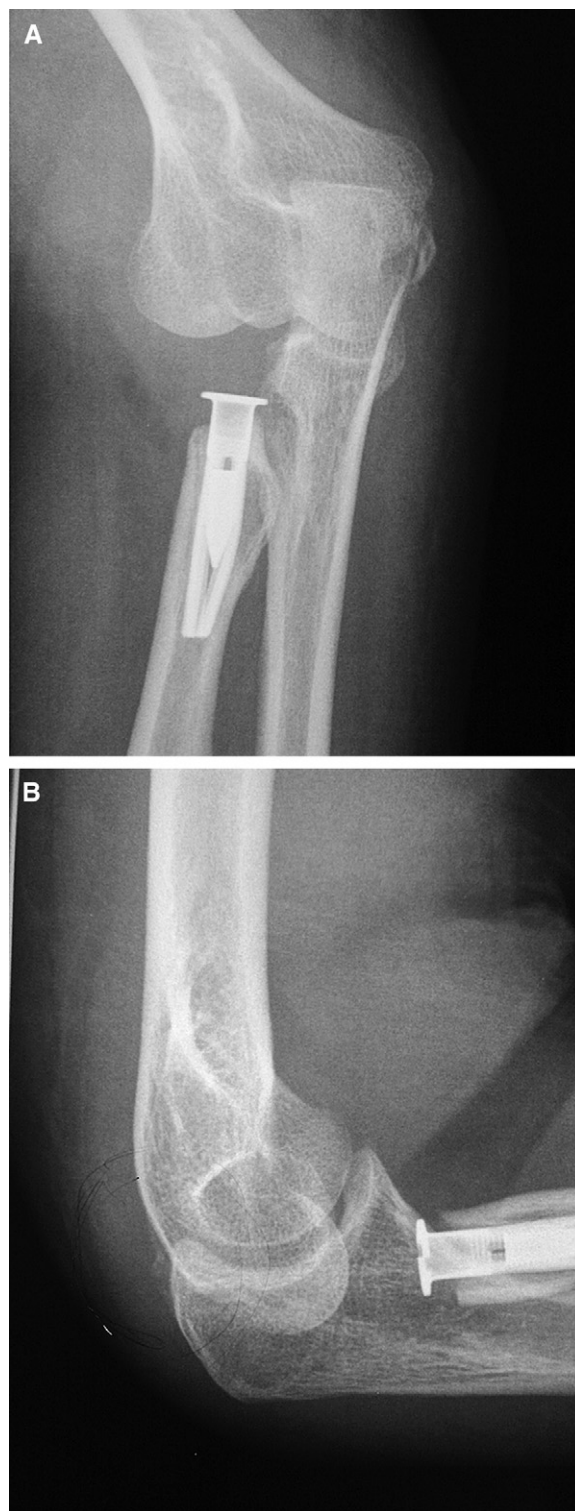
(A) Anteroposterior and (B) laterolateral radiographs show the elbow after the removal of the dissociated radial head of the prosthesis.
